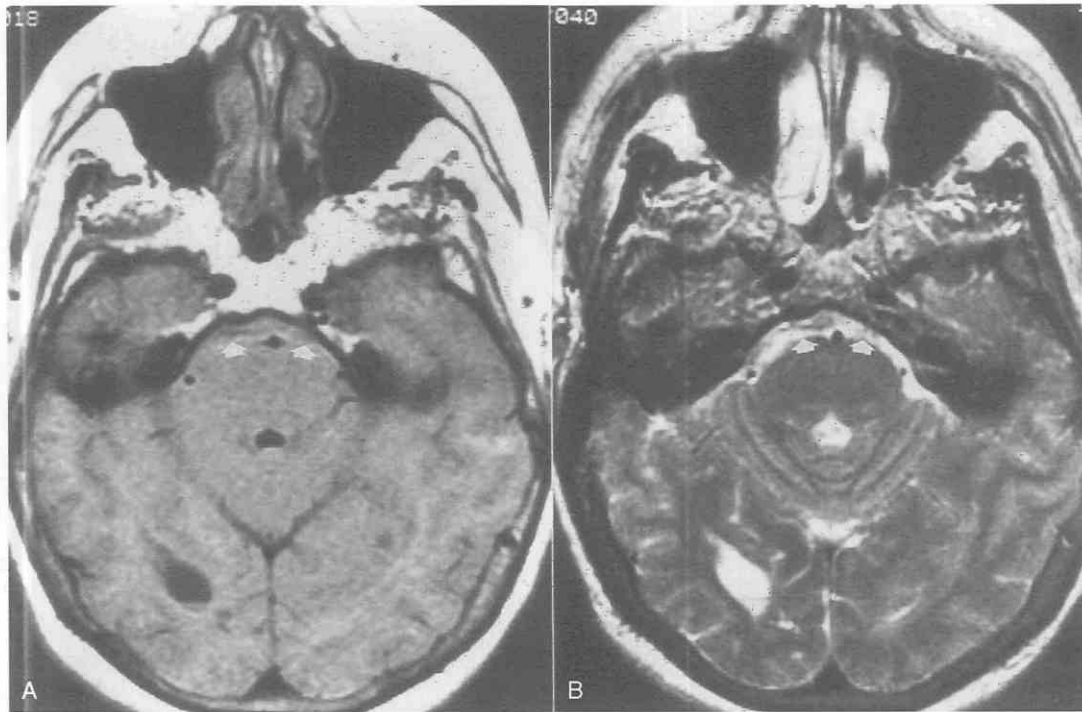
A, Acute subarachnoid hemorrhage in pontine cistern is isointense on axial T1-weighted (500/15) MR image (arrows). B, Hypointense hemorrhage is poorly seen on axial fast spin-echo T2-weighted (3900/108) image (arrows) because it is masked by hyperintense cerebrospinal fluid.
